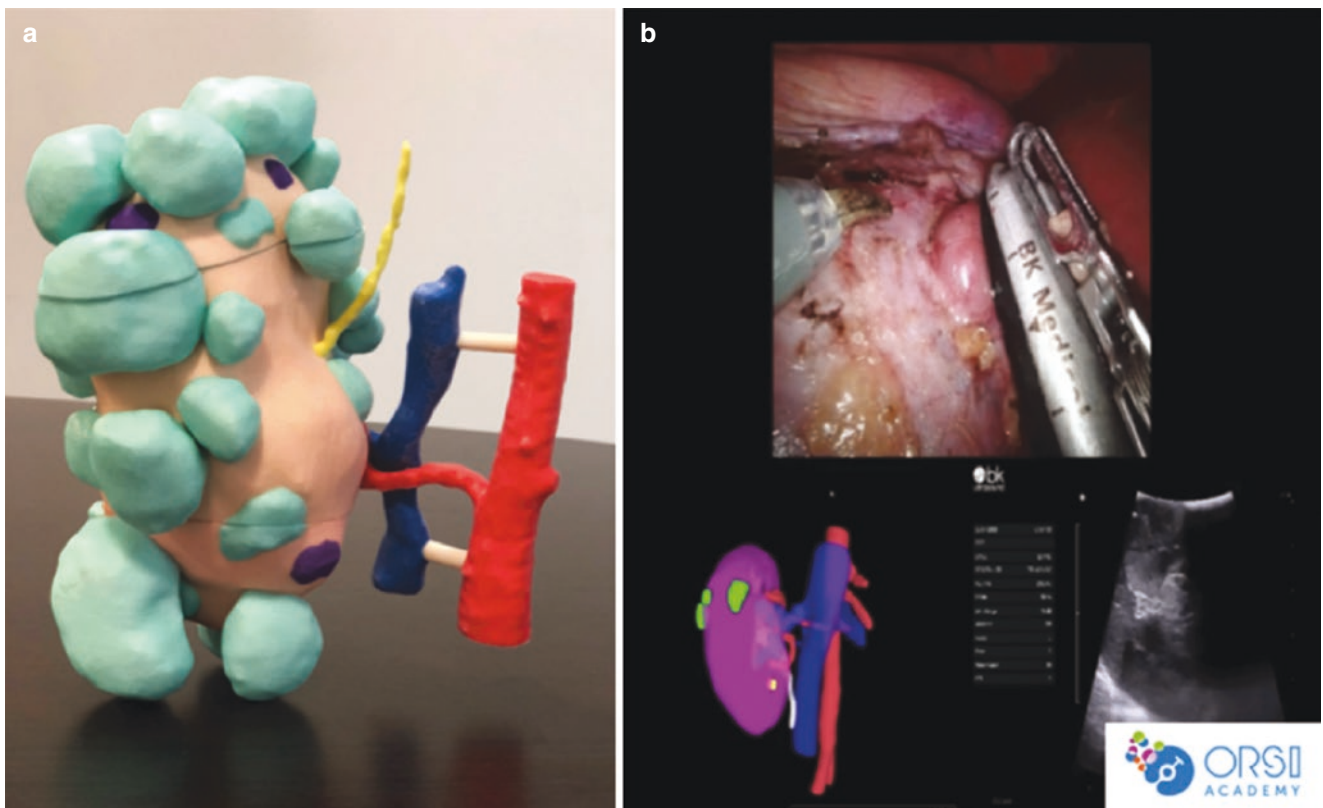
(a) 3D printed reconstruction model. (b) TilePro technology; superimposed images of the 3D printed model and ultrasound on the in vivo image are shown
